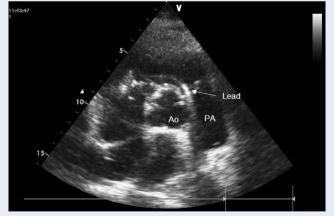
Parasternal short axis echocardiographic view demonstrated pacemaker lead stuck in the pulmonary artery (PA); Ao — aorta
